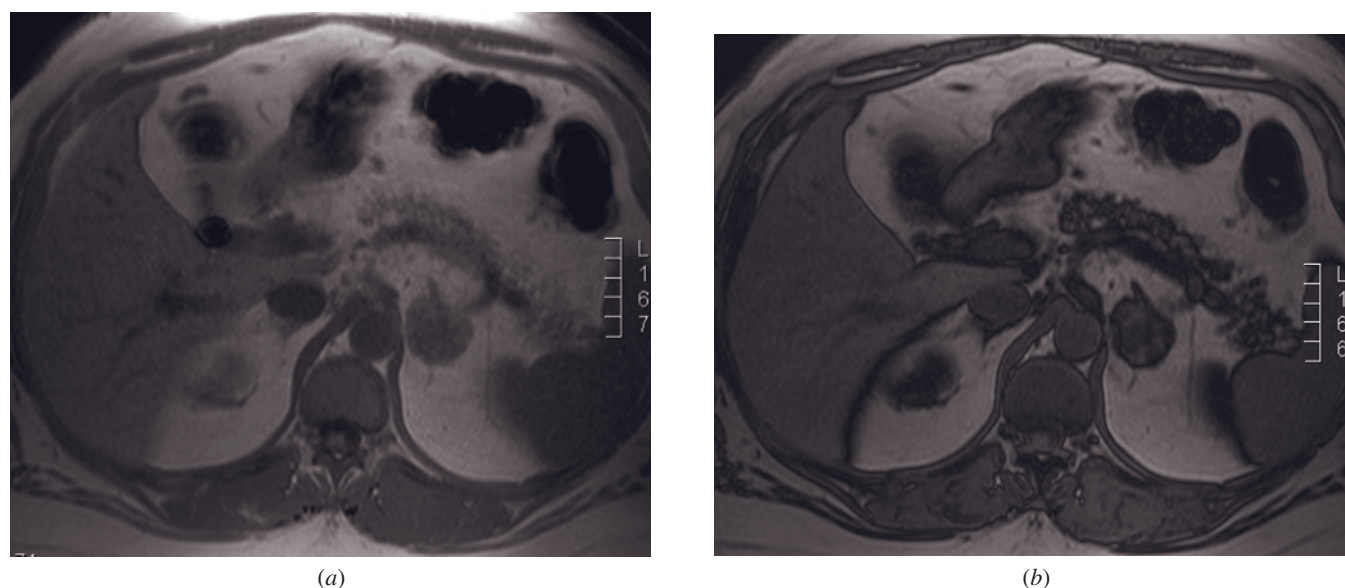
Adrenal adenoma—heterogeneous signal intensity and signal drop. T1-weighted GE (a) and T1-weighted out-of-phase GE (b) images. A left adrenal adenoma with heterogeneous signal intensity is noted on in-phase (a) image, with heterogeneous signal drop on out-of-phase (b) image. Heterogeneity should not be necessarily interpreted as a sign of malignancy.
